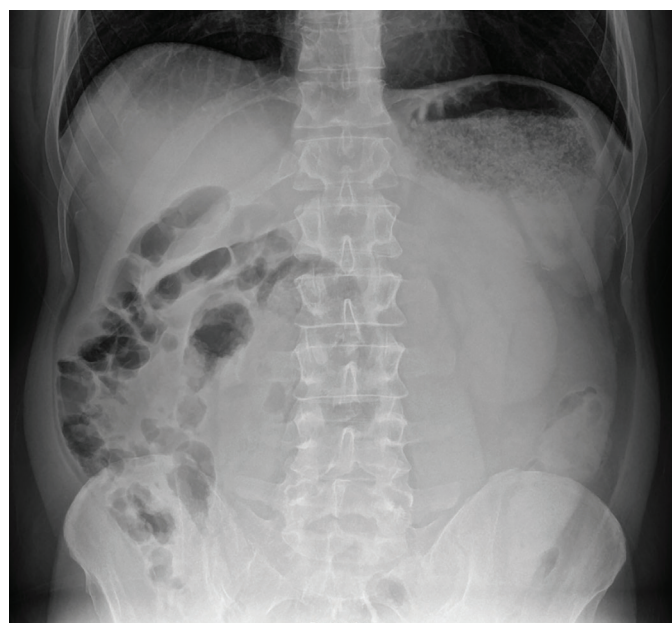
The upright abdominal radiograph reveals a nonspecific gas pattern in the small bowel in the upper right and lower quadrants
